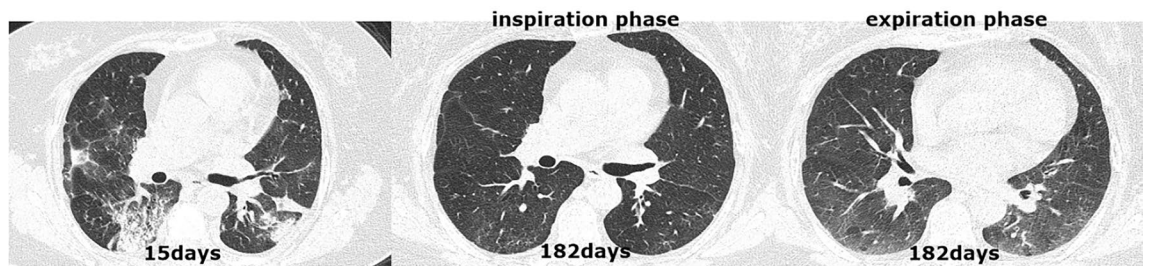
CT scan series in a 37-year-old COVID-19 patient with normal DL_{CO} (107.0%) at the 6-month follow-up. (a) Transverse CT scan obtained 15 days after the onset of symptoms showed multifocal ground-glass opacities in the left lung and right lower lobes. (b,c) Scans obtained during full inspiration and expiration on day 182 showed that previous opacifications were completely absorbed.
